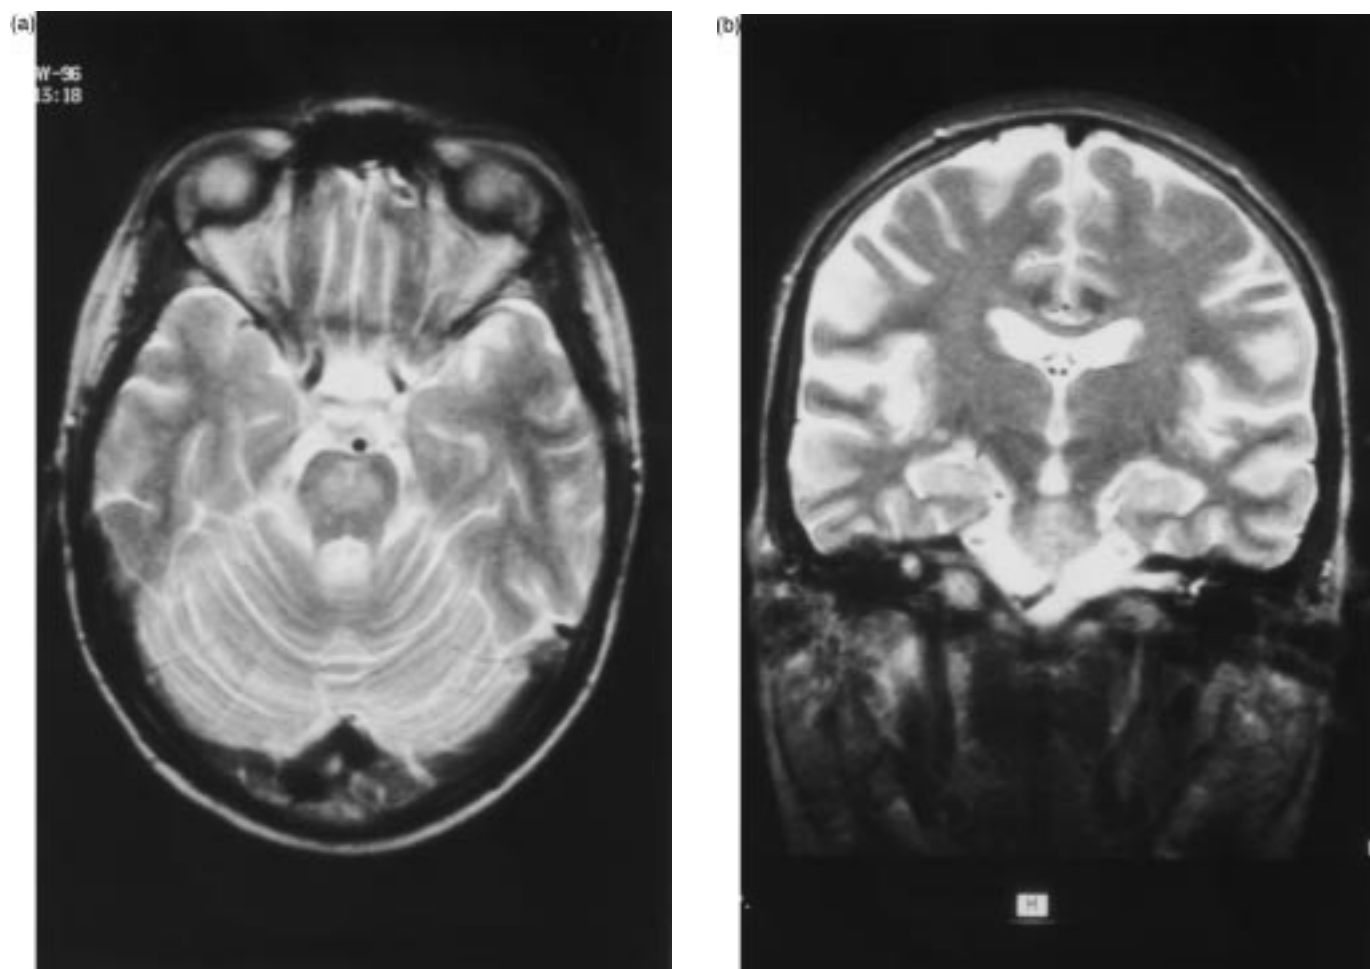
T2 weighted MRI image in (a) the axial and (b) coronal plane showing a large area of increased signal intensity in the centre of the pons
